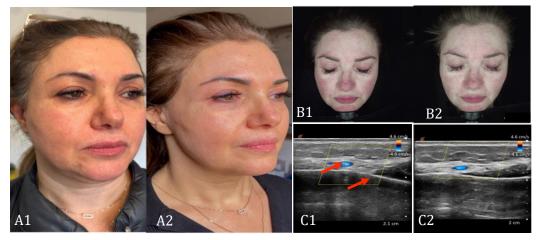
(A) Clinical photographs between pre-treatment (A1) and post-treatment (A2). The pre-treatment image reveals significant inflammatory changes associated with hyaluronic acid filler complications, characterised by erythema and uneven skin texture. The post-treatment image shows a marked improvement in overall facial appearance and skin quality. (B) OBSERV® 520X vascular imaging depicting the microvascular changes resulting from hyaluronidase intervention. The pre-treatment image (B1) exhibits extensive vascular congestion and diffuse erythema, while the post-treatment image (B2) demonstrates a normalisation of vascular patterns and reduced inflammatory response. (C) High-frequency ultrasound imaging at 2.1 cm depth capturing the soft tissue transformation. The pre-treatment scan (C1) reveals hyperechoic material with variable distribution in the deep dermis and superficial subcutaneous plane, characterised by heterogeneous echogenicity and disrupted normal tissue architecture. Red arrows in (C1) identify residual or migrated filler
